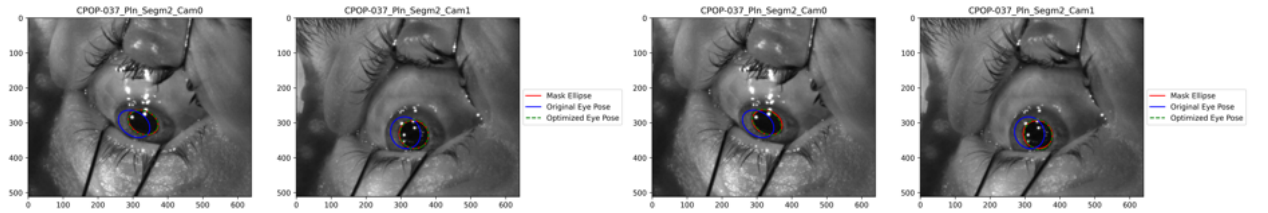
Patient CPOP-037 eye pose optimization for the original MRI model and the updated model respectively.
